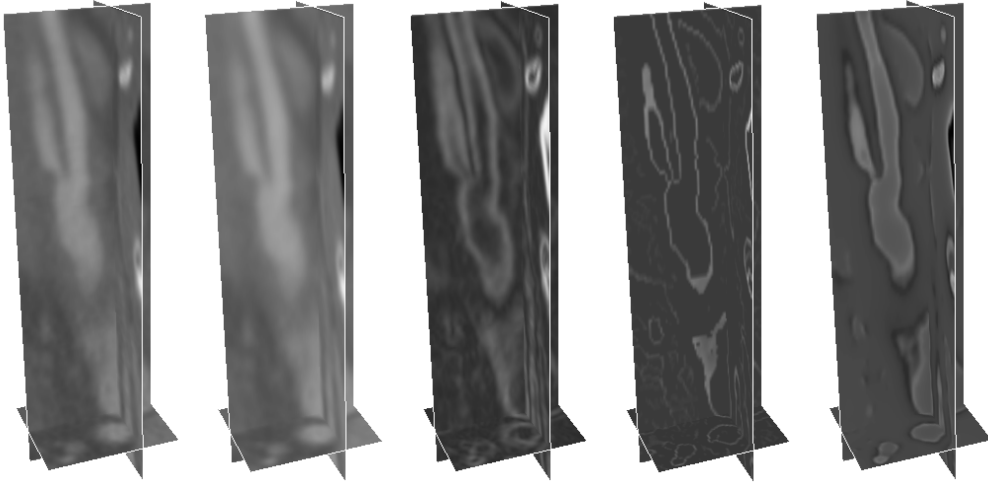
Vessel enhancing diffusion and image object edge representation of CT image dataset 1, from left to right - original image, image with vessel enhancing diffusion, image gradient magnitude, Canny edge with image gradient intensities, geometric potential field.
